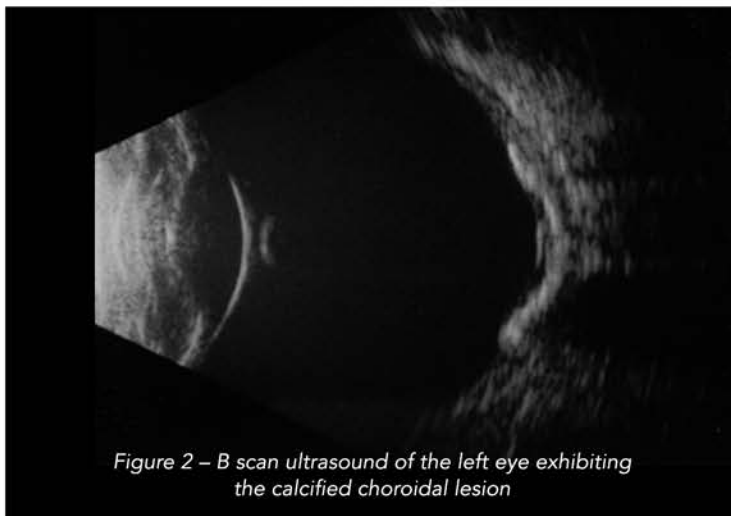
B scan ultrasound of the left eye exhibiting the calcified choroidal lesion
